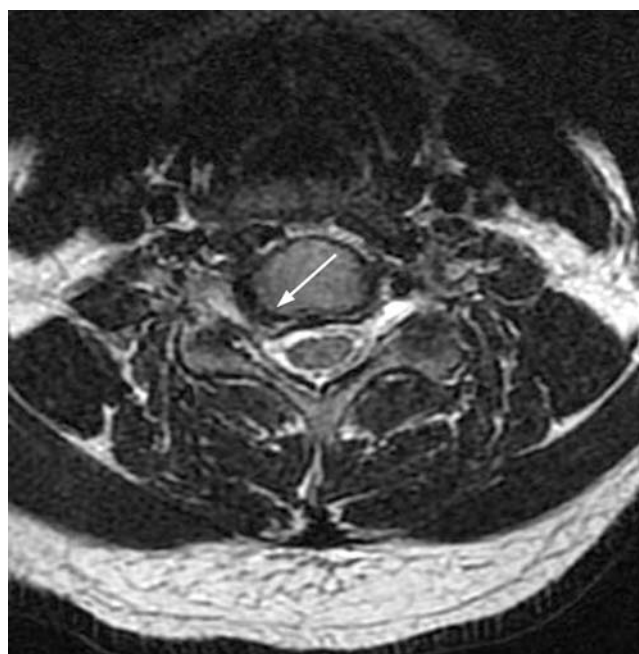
Axial T2-weighted MRI of the cervical spine showing a soft disk herniation causing significant neurologic impingement (arrow).
